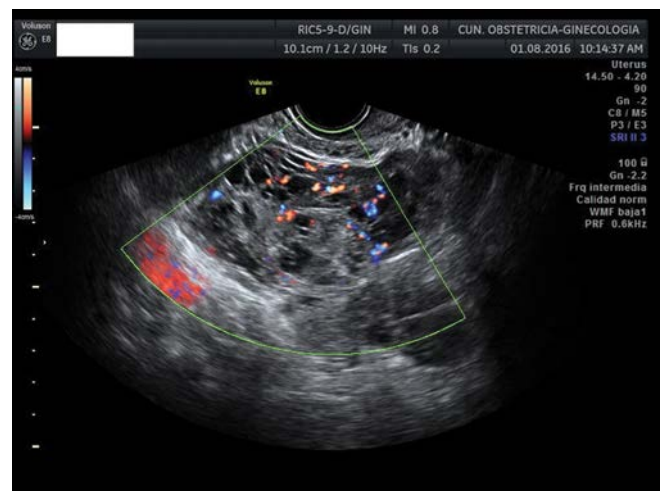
Transvaginal ultrasound in another case of endometrial stromal sarcoma. We can observe an irregular mass with cystic areas and moderate vascularization.
